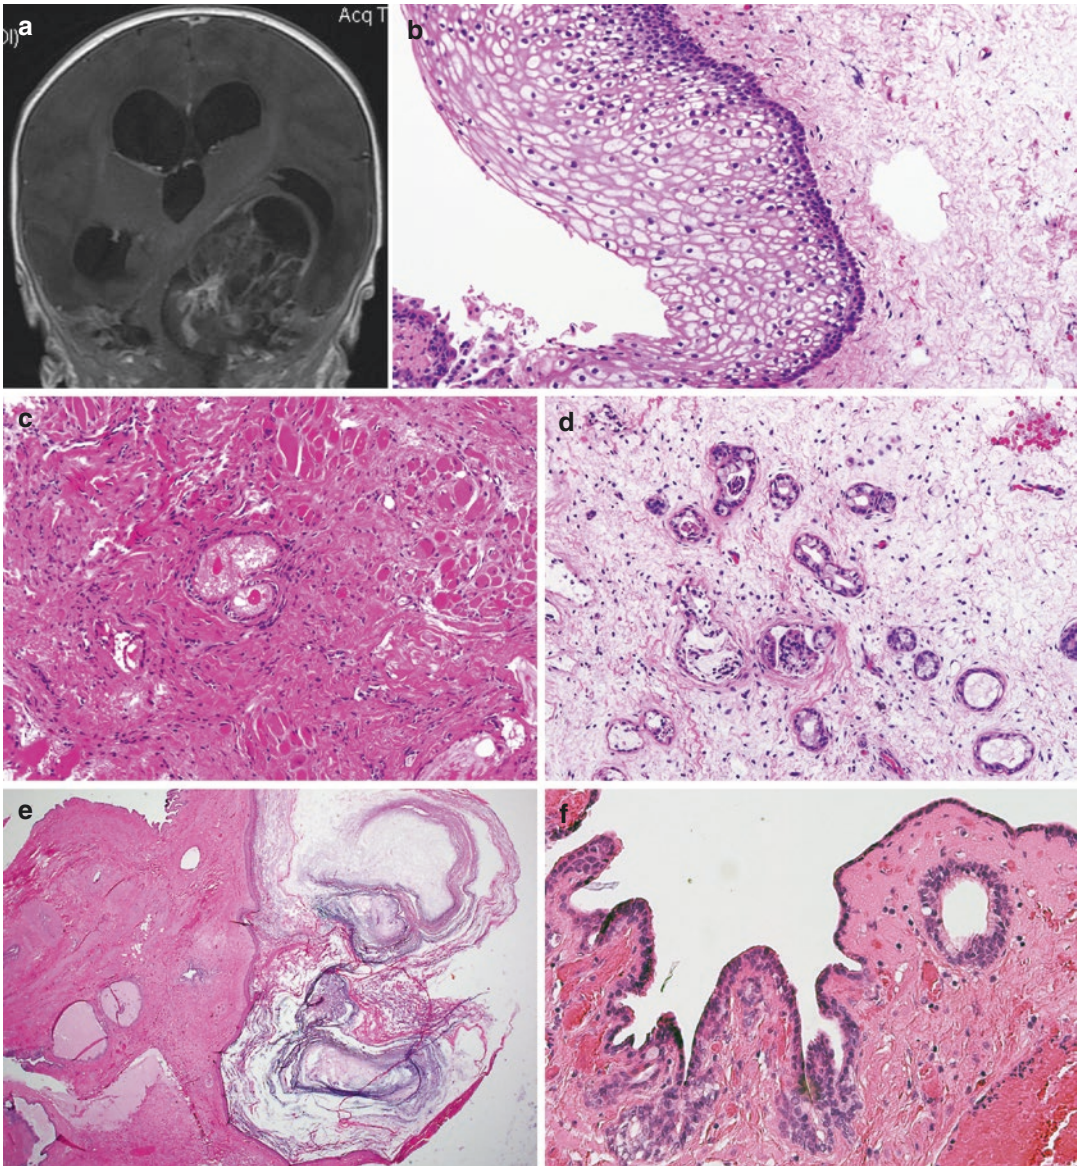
Intracranial mature teratoma. This mature teratoma formed a large heterogeneous mass in the skull base (T1-weighted MRI post-contrast) (a). Well-differentiated squamous epithelium is a feature of most teratomas (b).
